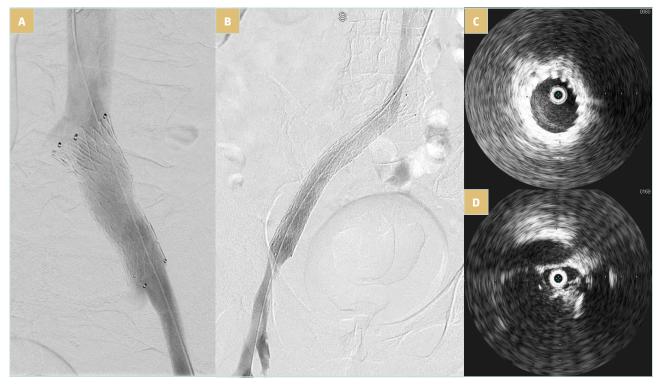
Venovo (BD Medical) stent placement after thrombectomy. A) Appropriate diameter of 16 mm, but short with a risk of migration; B) appropriate diameter of 16 mm and length of 120 mm; C) iliac vein compression after thrombectomy and before stenting as seen in intravascular ultrasound; D) well-expanded stent as seen in intravascular ultrasound.
